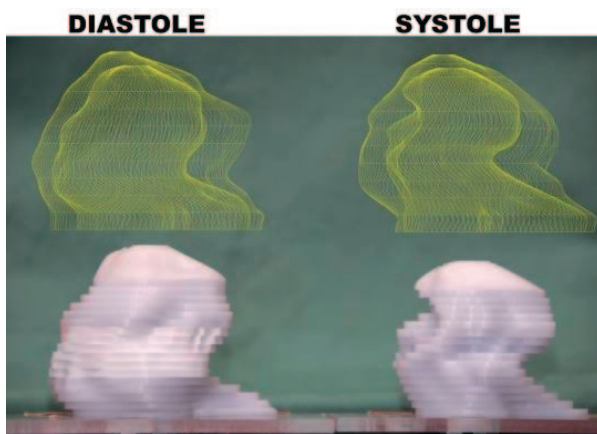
An example of the surfaces representing the patient's endocardial and epicardial shapes which is formed by 3D interpolation; these data were calculated by the interpolation of the measured data obtained in MR images.
